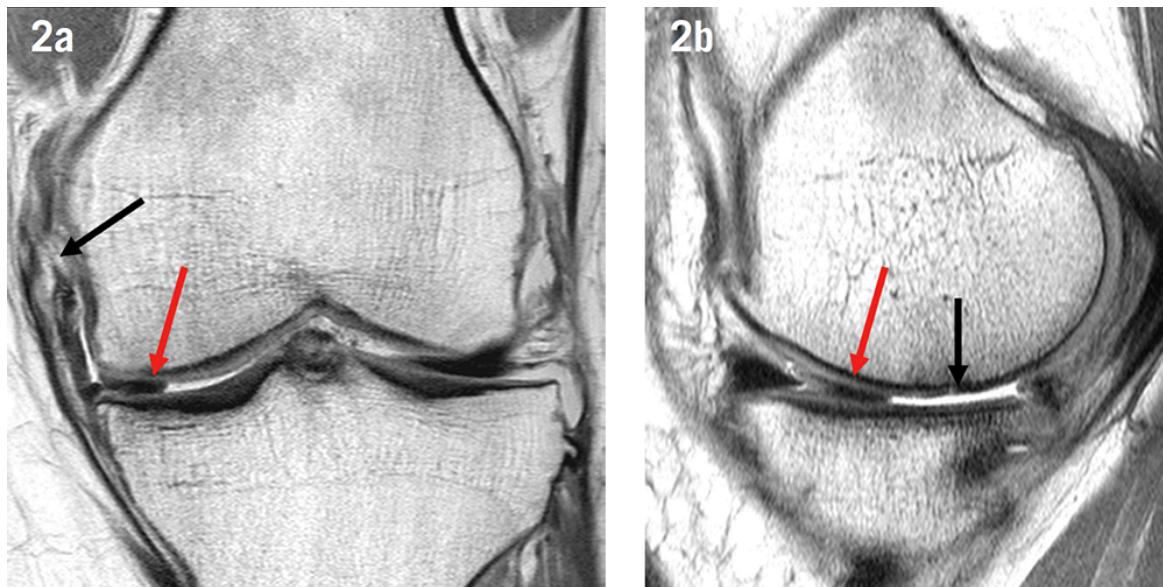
20-year-old basketball player. a) Coronal intermediate-weighted MRI shows an amputated posterior horn of the medial meniscus (red arrow) and medial collateral ligament tear (black arrow). b) Sagittal intermediate-weighted MRI shows shattered posterior horn of the medial meniscus with a meniscal fragment anteriorly displaced (red arrow) just posterior to the anterior horn. There is also partial thickness loss of the weight-bearing central medial femoral condyle (black arrow). Adapted with permission from Nielsen et al. (81)
